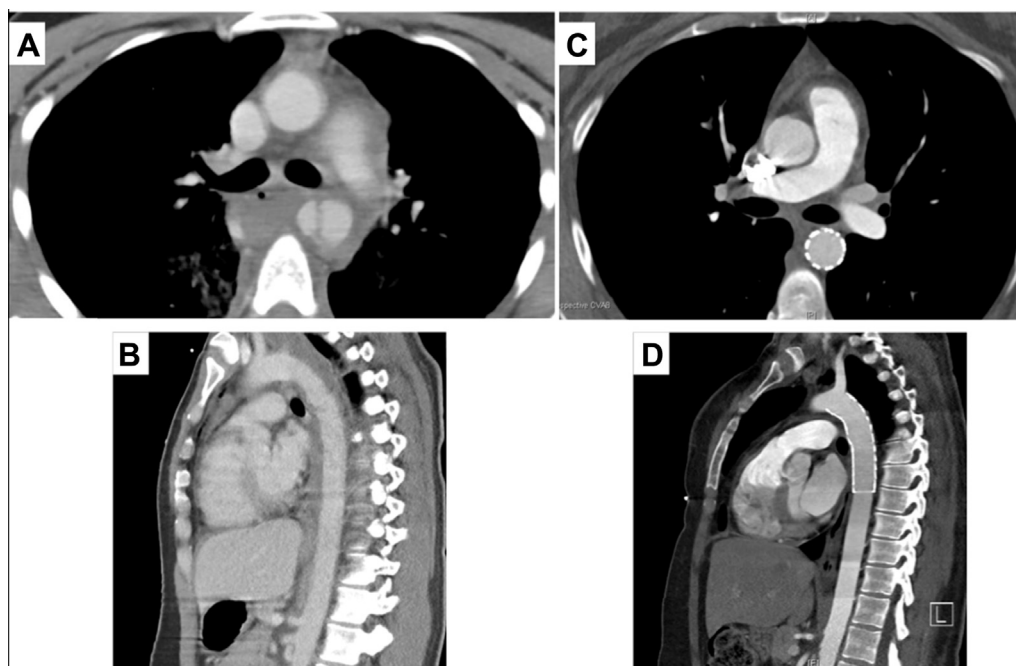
A and B, Trauma computed tomography (CT) scan showing moderate blunt aortic injury in axial and sagittal views. C and D, CT scan performed 1 year after thoracic endovascular aortic repair (TEVAR) showing aortic remodeling without any remaining pseudoaneurysm sac.
